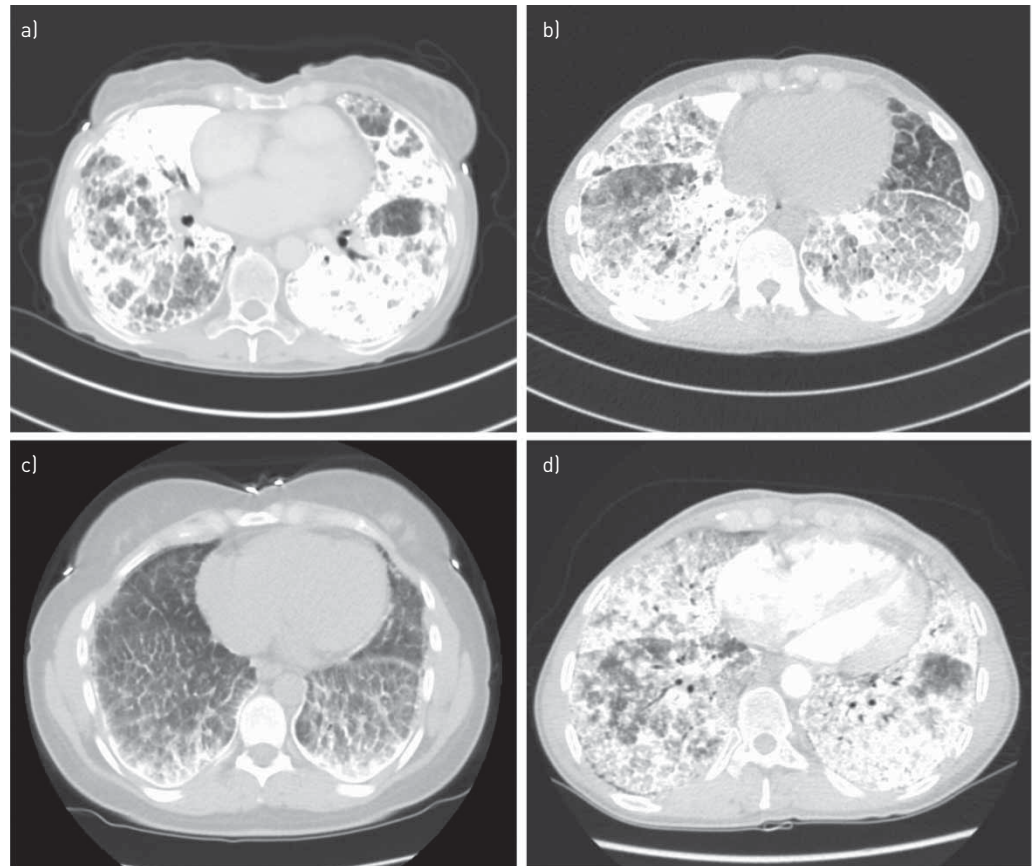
Computed tomography (CT) scans in pulmonary alveolar microlithiasis (PAM) patients showing different degrees of calcification with numerous sand-like calcifications, calcified interlobular septa and consolidations throughout the lungs with a subpleural localisation. Patient 12 (a) and patient 13 (b) are homozygous for the same genetic variant in *SLC34A2* and present with similar degrees of calcification in the lungs. Different levels of severity of lung involvement are seen in patient 1 (c) (mild clinical disease) and patient 7 (d) (severe clinical disease).
